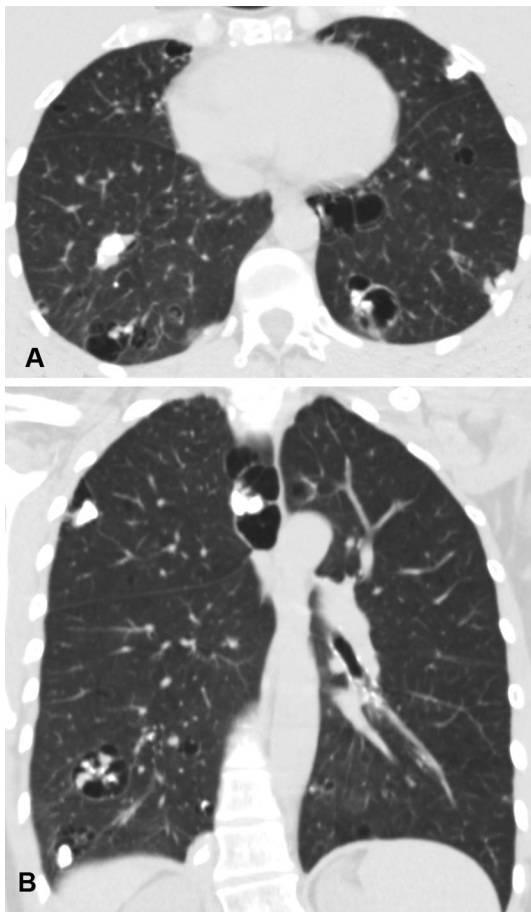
A 56-year-old woman with biopsy-confirmed amyloidosis. Coronal (a) and axial (b) CT images with lung window settings show multiple cysts and nodules. Note that some nodules are calcified and abut cyst walls, which is highly suggestive of an association with lymphoproliferative disease, particularly lymphocytic interstitial pneumonia and amyloidosis
